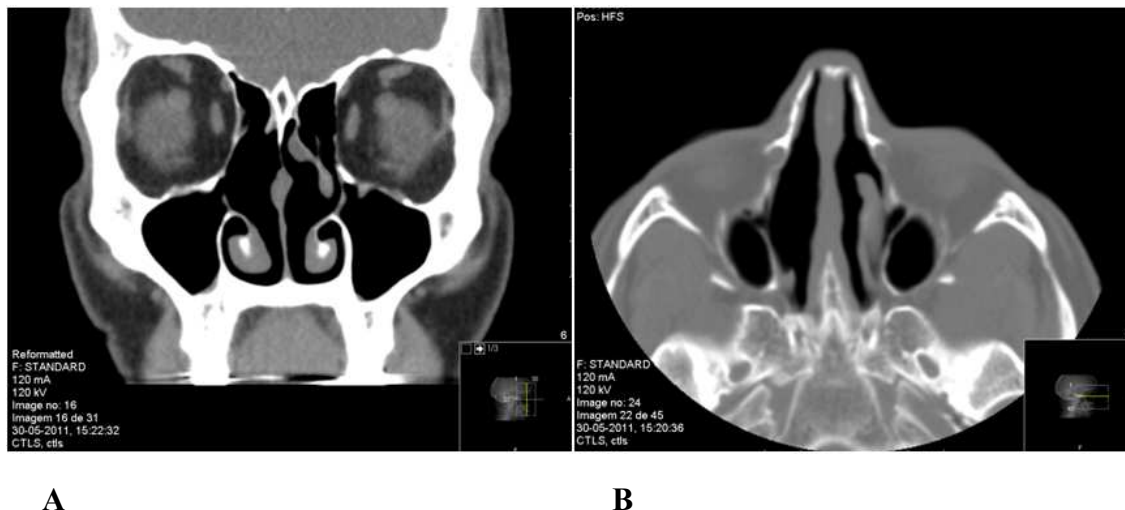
CT-scan of paranasal sinuses: coronal (A) and axial (B) views six months after surgery. These sections show good permeability of nasal cavity and paranasal sinuses without recurrence of the disease.
